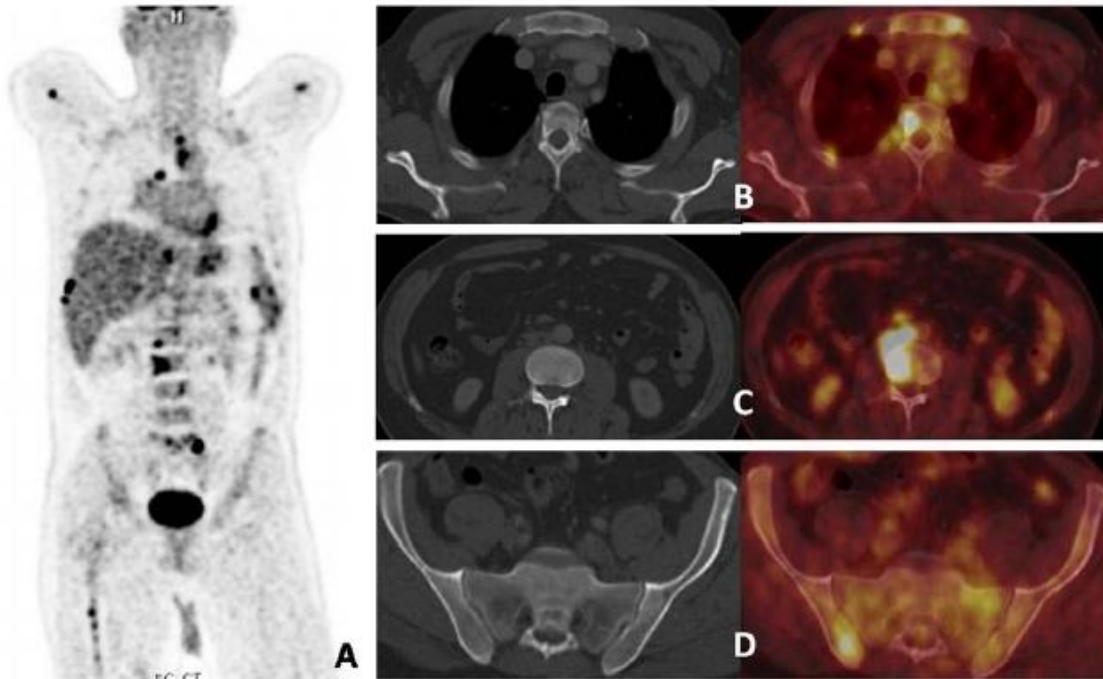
shows a male patient with NHL (A) MIP PET image reveals multiple focal areas of intense uptake denoting lymphomatous infiltrates. The axial CT and fused PET/CT images show: Multiple lymphomatous bony deposits at the sternum, right ribs and dorsal vertebral body with a left paratracheal lymph node (B) lumbar vertebral body with aortic and retrocausal lymph nodes (C) and right ischium (D) All the lymphoma bony deposits in this patient did not show any morphologic CT changes.
